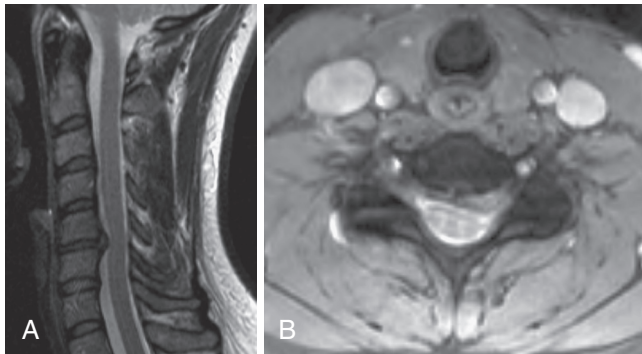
A and B, Magnetic resonance images of C5-6 soft cervical disc herniation.
